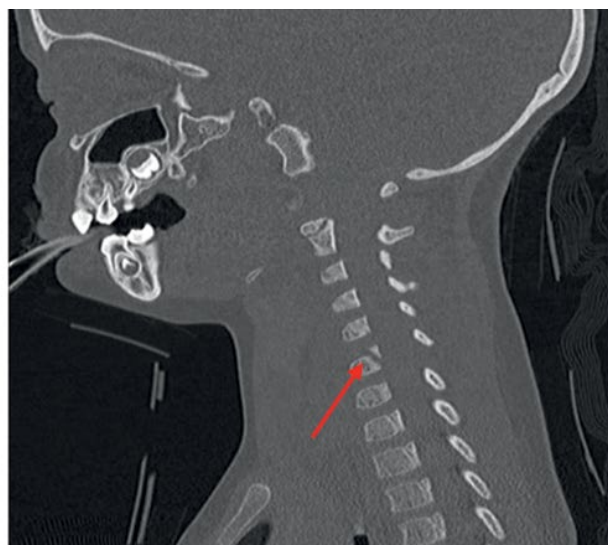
Lateral CT scan of the cervical spine of a 3-year-old girl following motor vehicle accident presents intubated in field with GCS of 3 and no spontaneous respiration. CT scan demonstrates a distraction injury, with abnormal widening of the joint space between the right occipital condyle and C1 lateral mass and between the right C1 and C2 lateral masses. Fracture through bilateral C6 vertebral body synchondroses (red arrow). There is associated paraspinal soft tissue swelling and focal hemorrhage in the C5–C6 disk.
